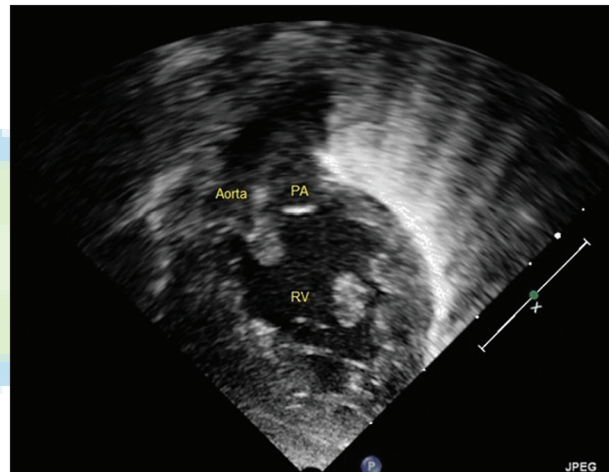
Two-dimensional subcostal transthoracic echocardiographic view is showing parallel D-transposed great vessels (aorta right anterior and pulmonary artery left posterior) originating from the well-developed right ventricle (double outlet right ventricle)
